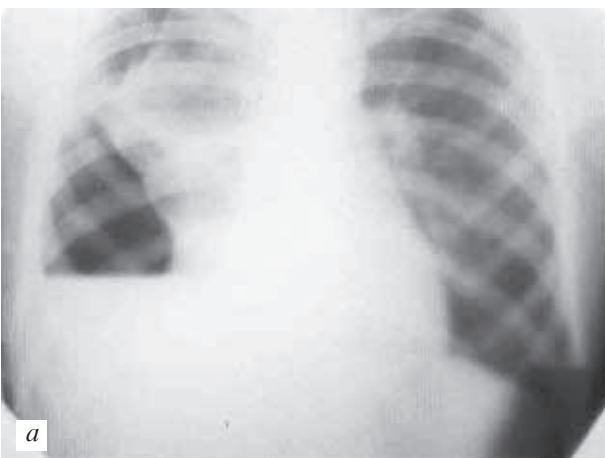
Chest roentgenogram, straight (a) and lateral (b) projection: right pyopneumothorax
